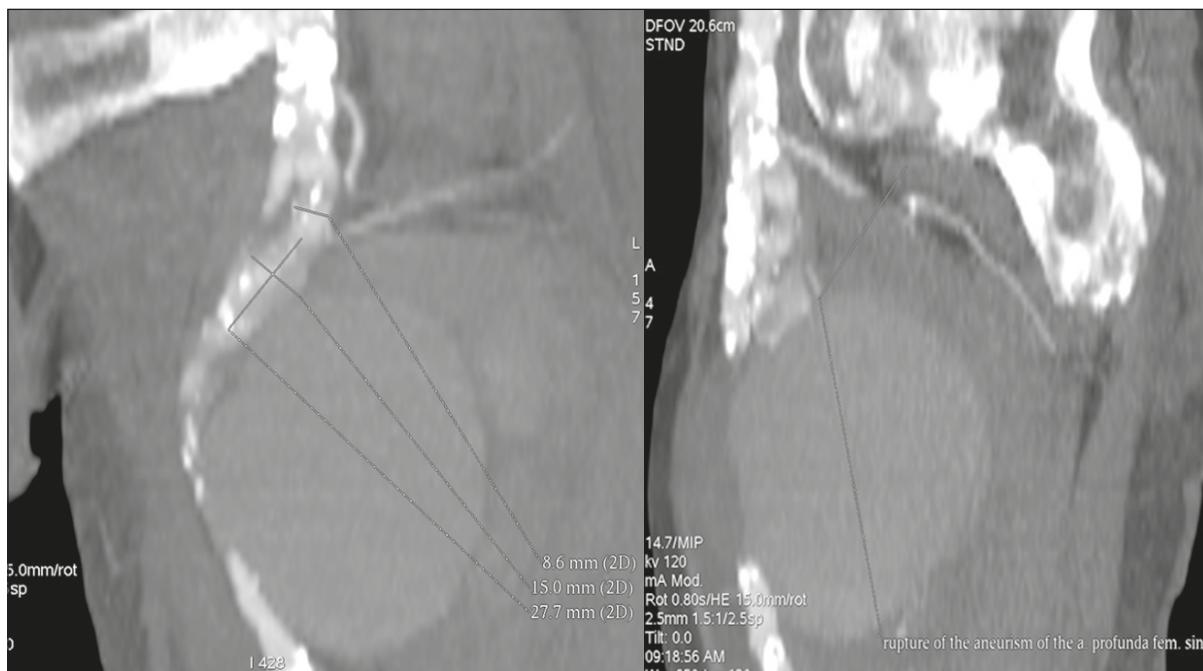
2D coronal and sagittal CT image showing the hematoma, the aneurysmal neck and the rupture of the left DFA aneurysm.
